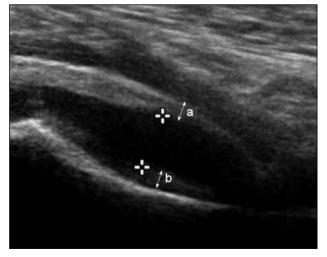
Ultrasound image of a patient with transient synovitis showing predominant joint effusion (cursors) relative to synovial thickening (distance a+b).
